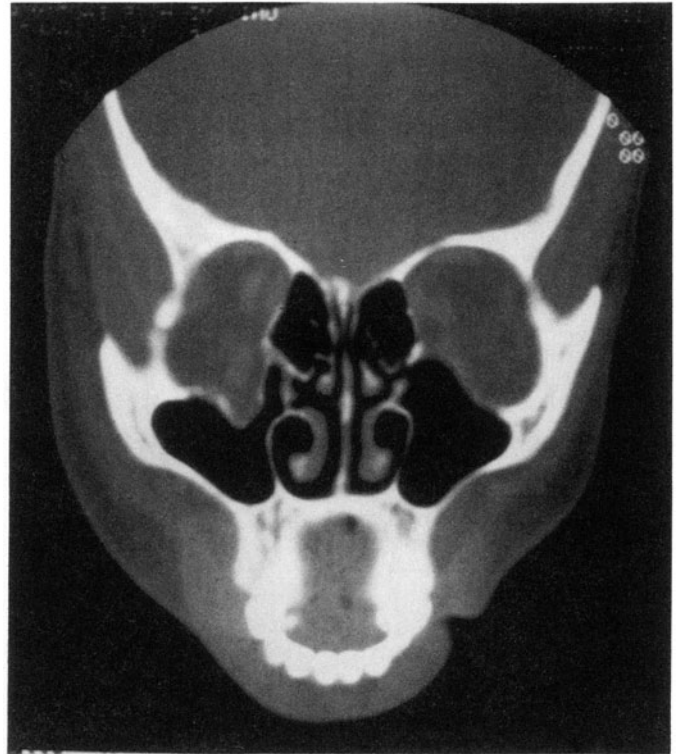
Coronal CT scan demonstrating fracture of the orbital floor with herniation of orbital contents into the maxillary antrum.
